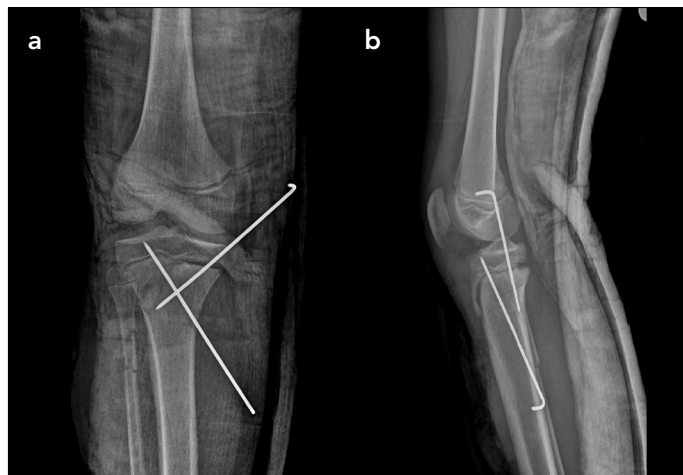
a, b. Radiography of the second case after early surgery
